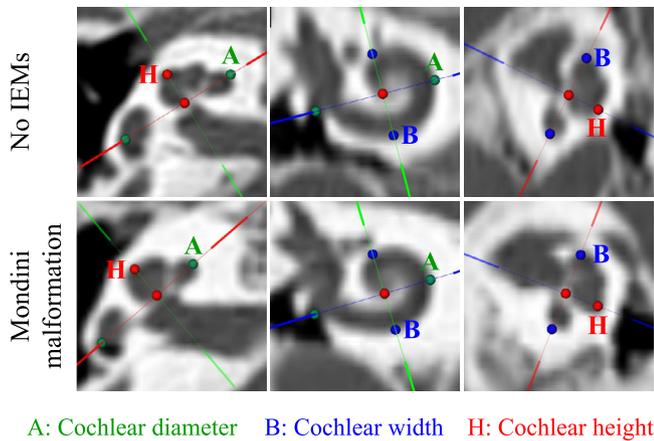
The OTOPLAN software reconstructed cochlear images based on high-resolution computed tomography from patients with (upper) no inner ear malformations (IEMs) and (lower) Mondini malformation. The A value (green dots) indicates the cochlear diameter, namely the distance between the midpoint of the round window passing through the mid-modiolus axis and the contralateral wall. The B value (blue dots) indicates the cochlear width measured as a straight line perpendicular to the basal cochlear diameter at the mid-modiolus. The H value (red dots) indicates the cochlear height measured as a straight line that starting from the basal point to the apical point.
